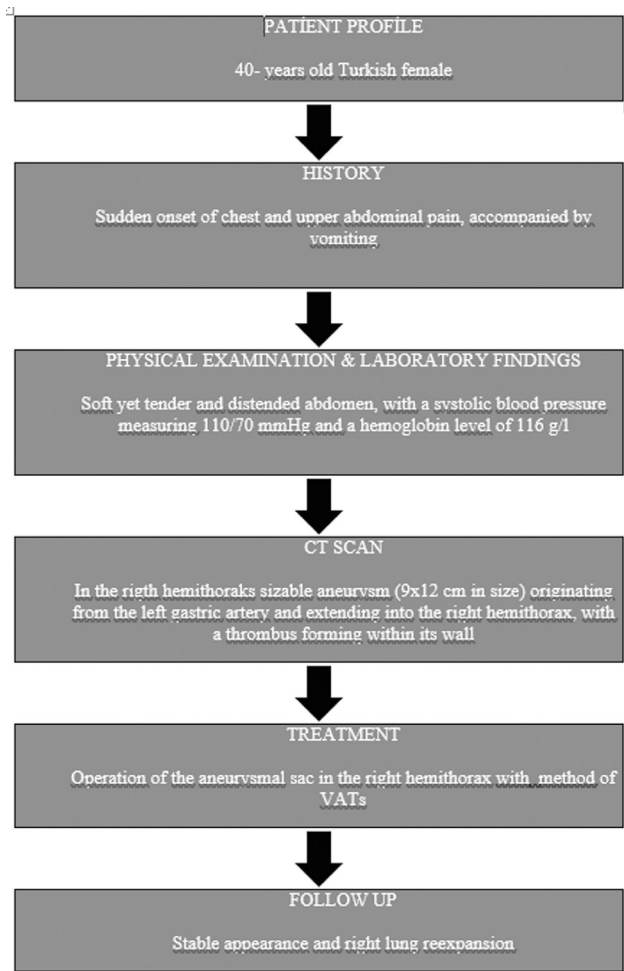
The timeline summarizes the patient's initial presentation, physical examination and laboratory findings, computed tomography scan, diagnosis, and treatment and follow-up.
